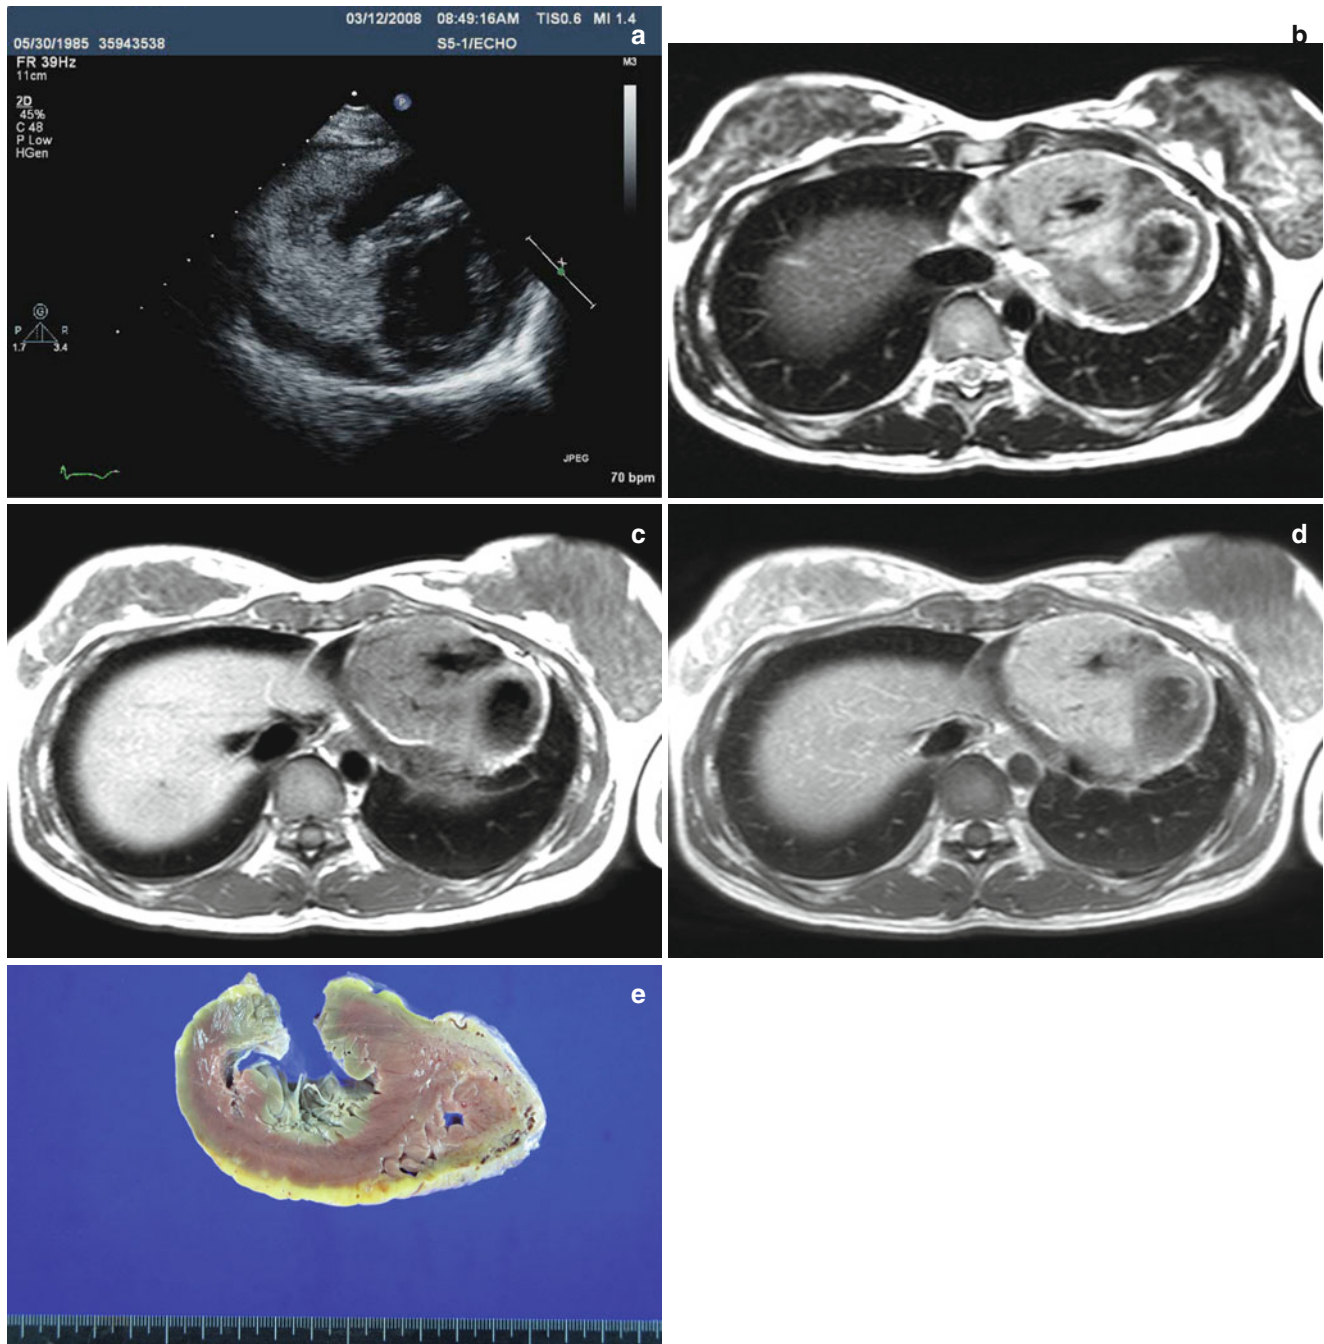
Imaging findings of capillary hemangioma located in the myocardium-F24. (a) Short-axis image using transthoracic echocardiography shows highly echogenic, infiltrative mass at the right ventricle (<http://extras.springer.com/2015/978-3-642-36396-2>). (b) T2-weighted MR axial image shows a homogeneously hyper-signal intensity mass at the right ventricle. (c) T1-weighted MR axial image shows slightly
